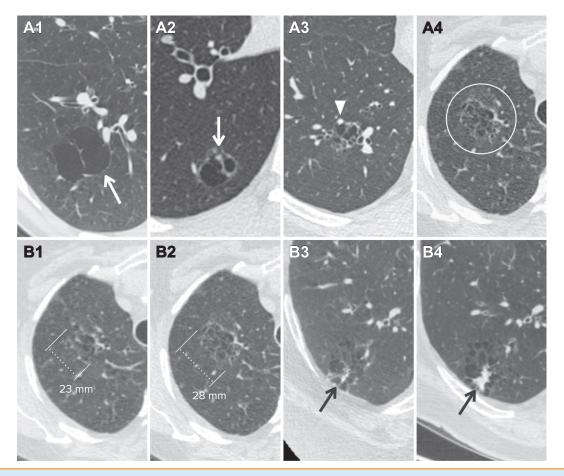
Atypical pulmonary cysts: multilocular. (A) Multilocular cysts are heterogeneous in appearance, contain internal septations (A1, A2, A3, A4), and may have solid or ground glass components such as thick walls (A2, arrow), nodules (A3, arrowhead), or internal opacities (circle). Multilocular cysts are classified as Lung CT Screening Reporting and Data System (Lung-RADS) category 4A at baseline. (B) A 68-year-old patient with a 23-mm mean diameter multilocular cyst at baseline (B1), which grew to 28 mm at 12-month CT screening (B2). A 56-year-old patient with a multilocular cyst containing a solid component at baseline (B3, arrow) that grew on follow-up screening (B4, arrow). Multilocular cysts that grow (>1.5-mm increase in mean diameter), have increased loculation, or have new or increased opacities are very suspicious for malignancy and are classified as Lung-RADS 4B.
